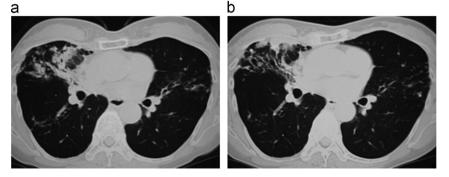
Chest CT images taken at different times during the course of treatment. (a) 1st day of illness, at first presentation. (b) 21st day of illness, after removal of EWS.
